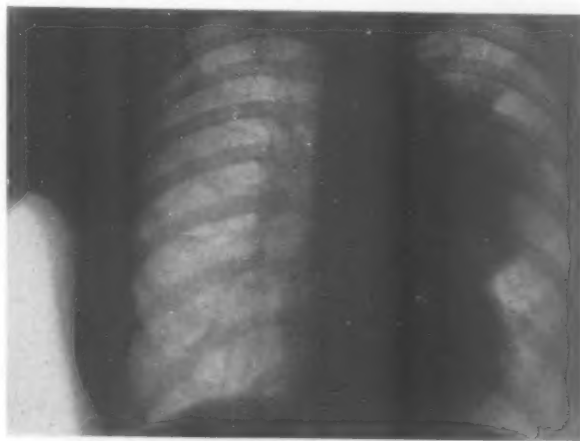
X-ray of chest, September 7, 1926, when the tumor had almost reached the lateral chest wall and first showed lobulation.
